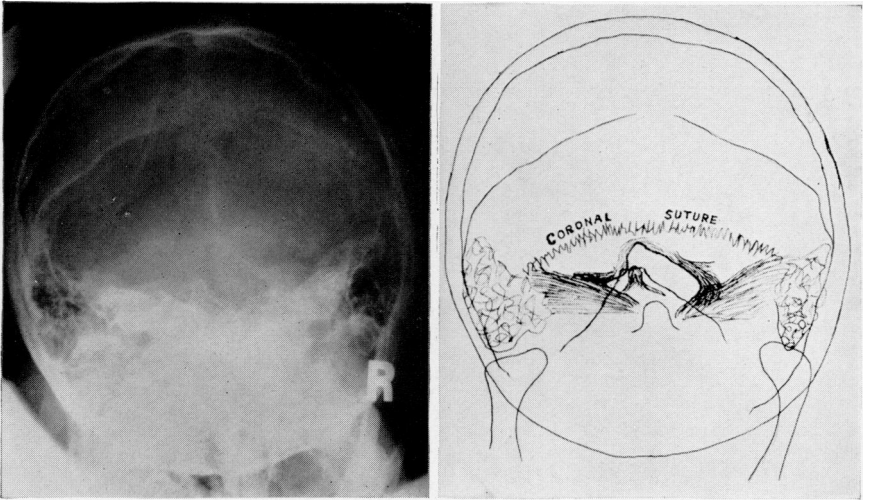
a-b. *Left*: Fronto-vertex projection of skull in platybasia (Case I). Central ray of x-ray beam enters skull at dorsal margin of foramen magnum and projects the shadow of this part upon the film through the frontal bone near the coronal suture. *Right*: Tracing from same. Note the deformity and stenosis of the foramen magnum. This patient's symptomatology and neurologic findings were characteristic of syringomyelia.
